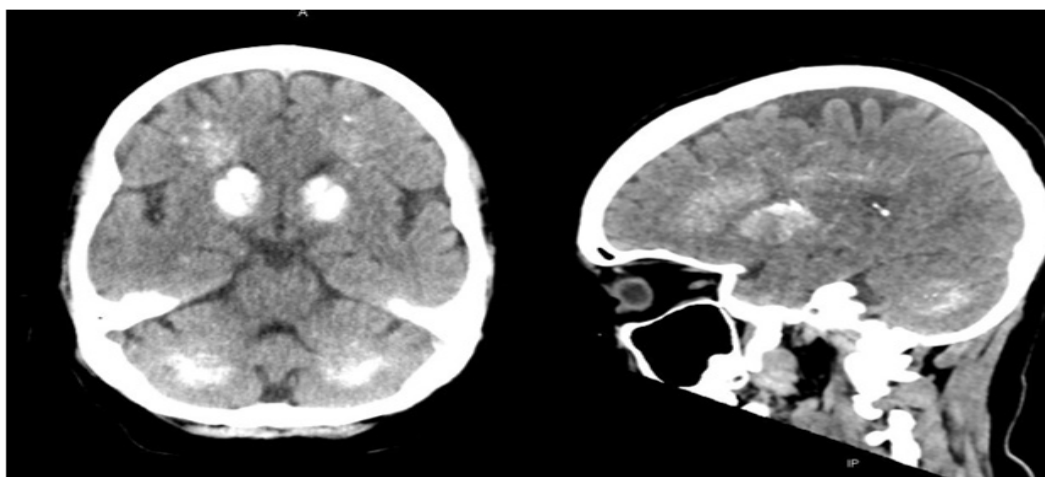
Computed tomography of the skull showing a decrease in the cortico-subcortical region, hyperdense lesions are evident in the basal ganglia suggestive of calcifications at this level.
